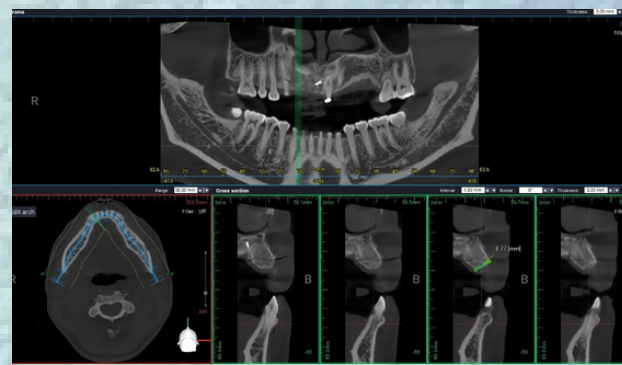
a,b: CBCT cross section images showing bone width was achieved: 8.77 mm and an apico-coronal height of 17.96 mm
